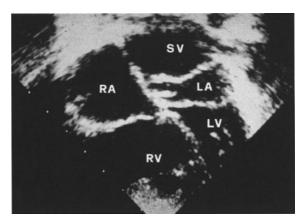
Cor triatriatum: echocardiography. The 4-chamber view shows the diaphragm dividing the left atrium into two components: the proximal (superior) left atrial chamber, above the subdividing diaphragm, receiving the four pulmonary veins (SV sinus venosus) and the distal (inferior) left atrial chamber with the left auricular appendage and the mitral valve (LA distal (inferior) left atrium, LV left ventricle, RA right atrium, RV right ventricle, SV sinus venosus (collecting the four pulmonary veins)) (photograph courtesy of Dr. Nicole Sekarski)
